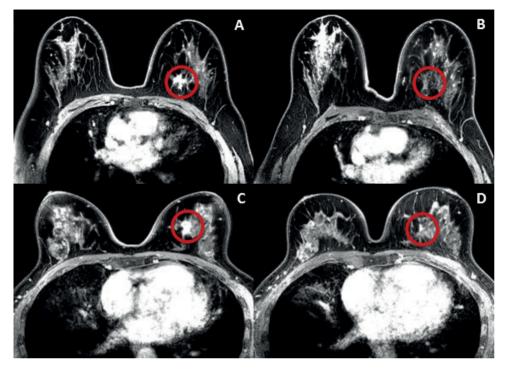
A: Diagnostic DCE-MRI of patient 1; B: DCE-MRI at 6 months following NA-PBI showing radiologic complete response in patient 1; C: Diagnostic DCE-MRI of patient 2; D: DCE-MRI at 6 months following NA-PBI showing residual disease in patient 2.
